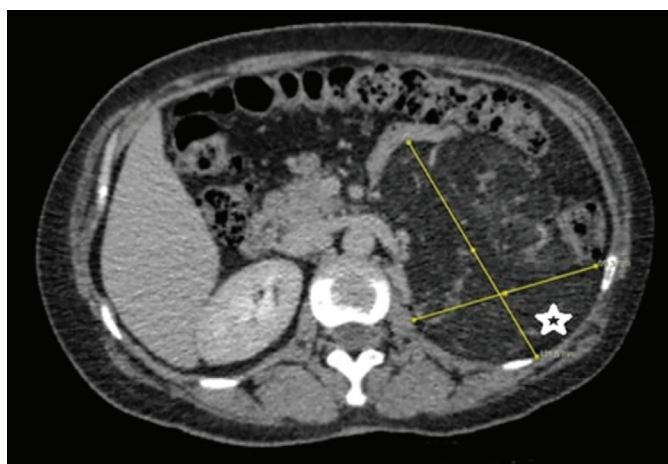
Late-phase images of multiphase renal computed tomography examination; a mass consistent with angiomyolipoma with heterogeneous density, located in the left retroperitoneal area, measuring 131x99x137 mm, well-defined, lobulated contours, and containing dense fatty content (indicated with a star)
